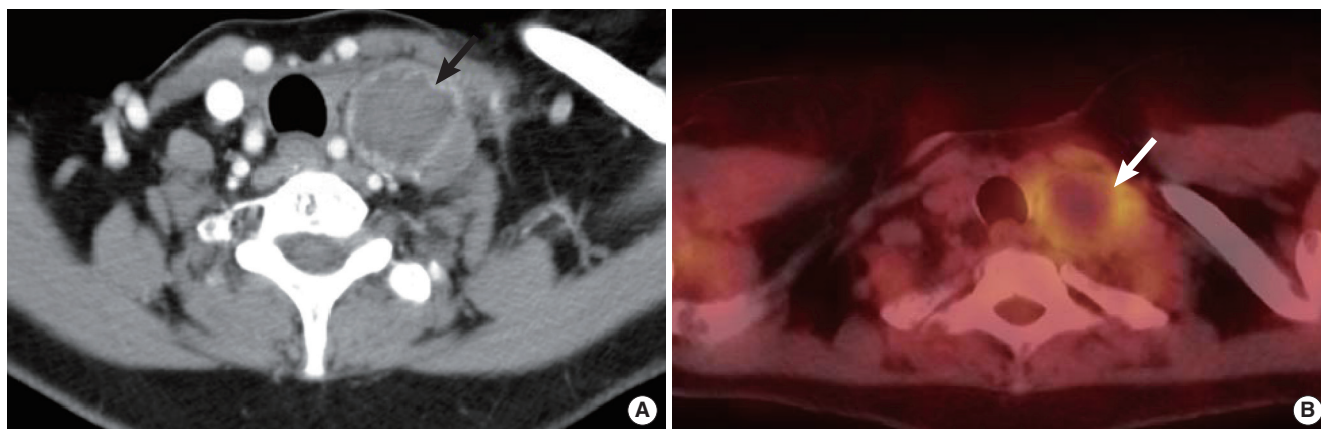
The radiologic findings of retained gauze. (A) Neck computed tomography (CT) shows a low attenuating homogenous central mass with a hyperdense, well-enhancing, irregular rim. (B) Positron emission tomography/CT depicts the hot uptake on the rim of the left supraclavicular mass and no uptake on internal area of mass.
